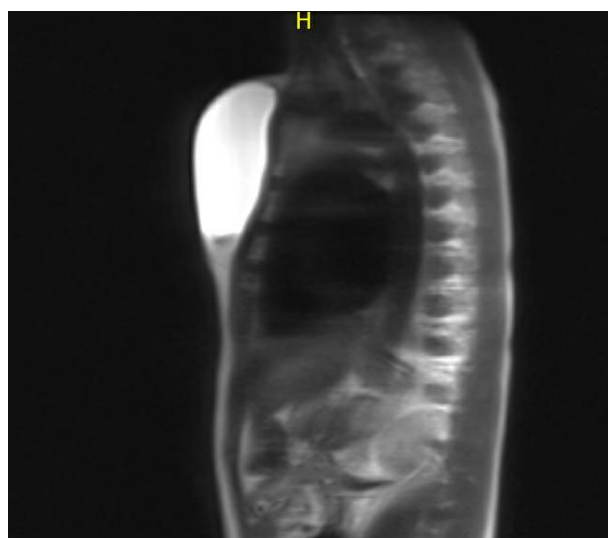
Mid-sagittal view on MRI demonstrating the vertical extent of the cyst.
